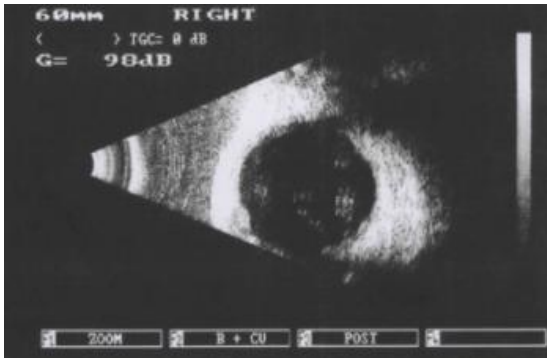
Ultrasound; right eye, lesion of medium reflectivity on the fundus periphery of the eye that is in direct contact with the epibulbar lesion
